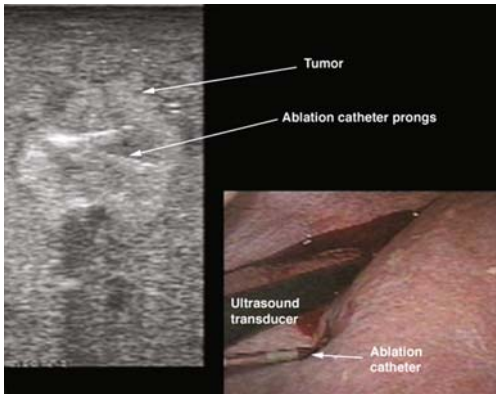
Ultrasound image of ablation catheter in lesion with prongs deployed.
